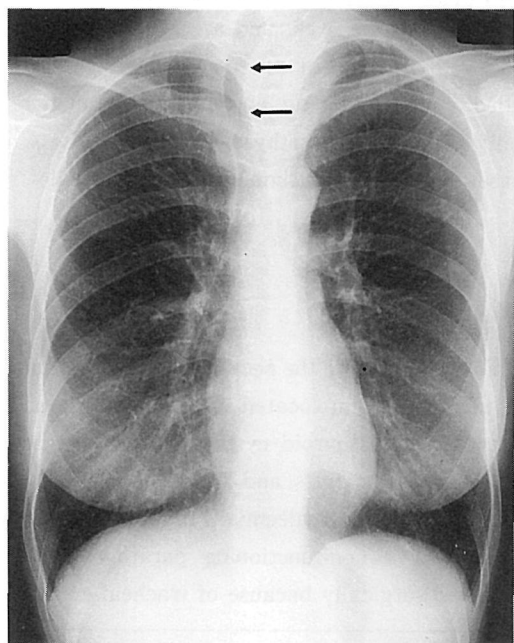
Radiograph of the chest showing right deviation of the trachea (arrows).
